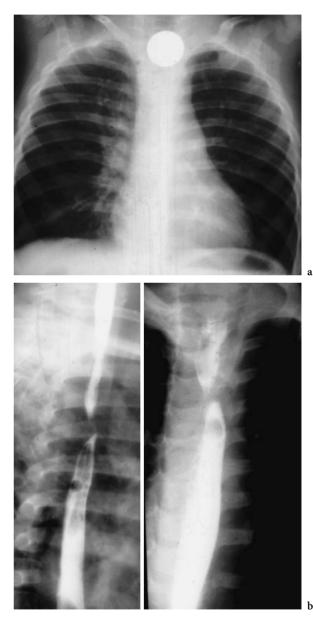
Impacted coin above an unsuspected vascular ring. a Frontal chest radiograph shows the coin lodged in the proximal esophagus above the aortic arch. b Barium esophagram reveals an aberrant retroesophageal right subclavian artery
